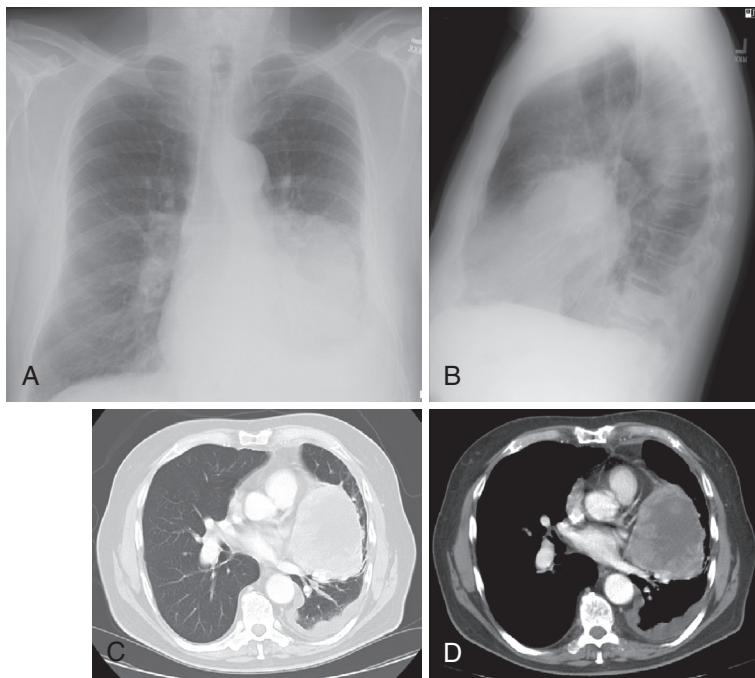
Imaging non-small cell lung cancer. A,B, Posteroanterior and lateral chest radiogram of patients with non-small cell lung cancer which is locally advanced. C,D Computed tomography (CT) imaging using lung and mediastinal windows. (From Abeloff M, et al. *Abeloff's clinical oncology*. 4th ed. Philadelphia: Churchill Livingstone, 2008, Fig. 76-12.)
